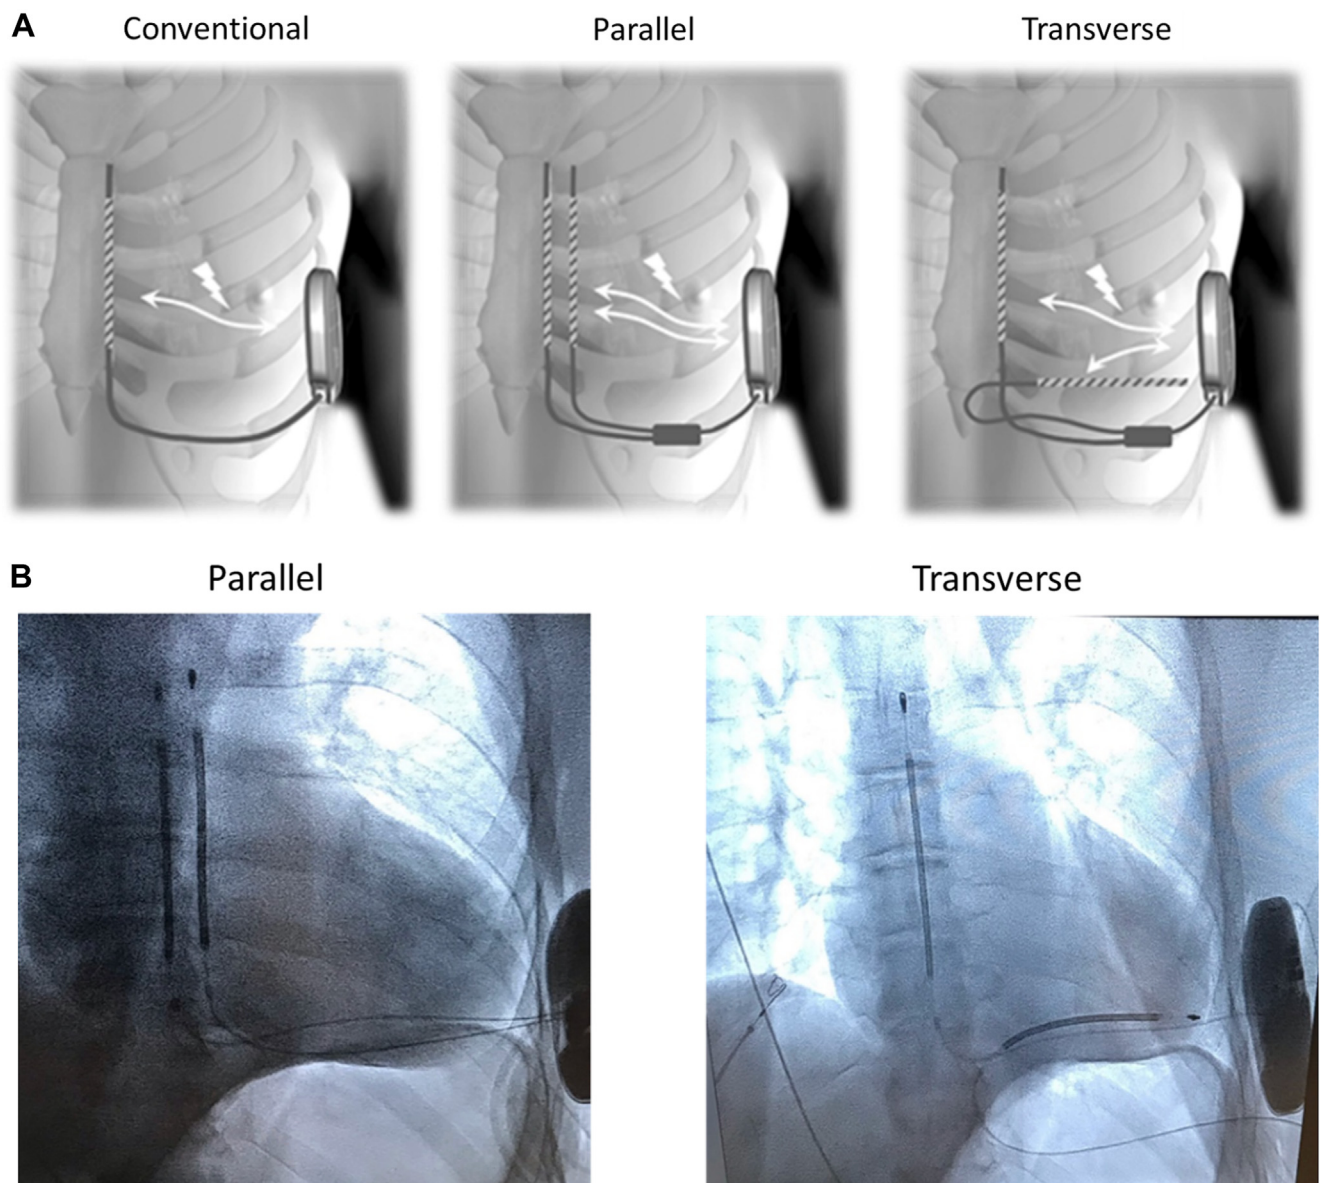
A: Subcutaneous implantable cardioverter-defibrillator (S-ICD) shock configurations. The conventional S-ICD configuration was a single left parasternal electrode and S-ICD pulse generator, as used for all current S-ICD systems. Parallel and transverse configurations added a second coil electrode for testing of new dual electrode configurations in this study. B: Fluorographic images of 1 tested patient, showing parallel and transverse electrode locations.
